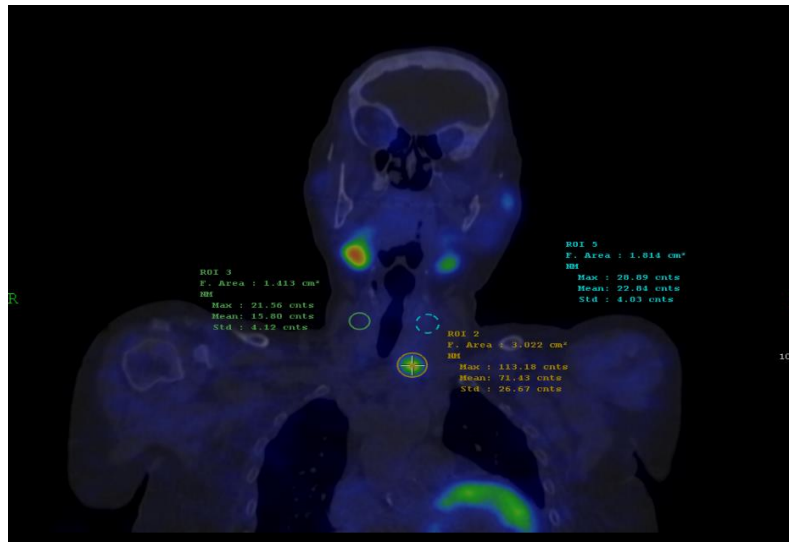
Coronal fused SPECT/CT image demonstrating focal ^{99m}Tc -MIBI uptake in the target parathyroid lesion. Semi-quantitative analysis was performed using manually defined regions of interest (ROIs), with ROI 2 placed over the lesion and ROI 1 and ROI 3 positioned in adjacent background tissue. The target-to-background ratio (TBR) was calculated by dividing the mean counts of the lesion ROI (73.43 counts) by the average mean counts of the two background ROIs (23.04 and 15.80 counts), yielding a TBR of 3.78. This demonstrate that there is an increase in the tracer concentration in the lesion compared to other surrounding tissue.
